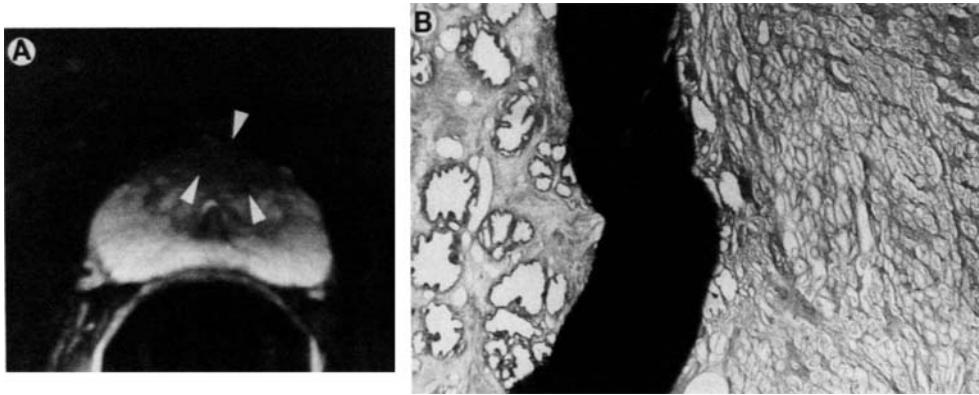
A, axial T2-weighted image shows carcinoma in anterior part of prostate (arrowheads). B, same tumor tissue seen on right side, normal glands on left side. Reduced from $\times 20$.
